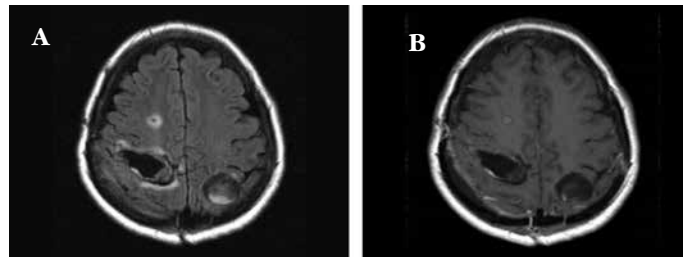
2B. Postoperatif dönemde. FLAIR T2 ve B. Postkontrast T1 ağırlıklı aksiyal kesitlerde kistlerin operasyon ile boşaltıldığı ve operasyon lojunda sıvı birikimi olduğu görülmektedir. Sağ frontalde ise 5 mm çaplı periferik kontrast tutan lezyon izlenmiş olup bu lezyon preoperatif MRG'deki boyutlarına göre hafifçe büyüyen rezidü enfekte hidatik kisti temsil etmektedir.
